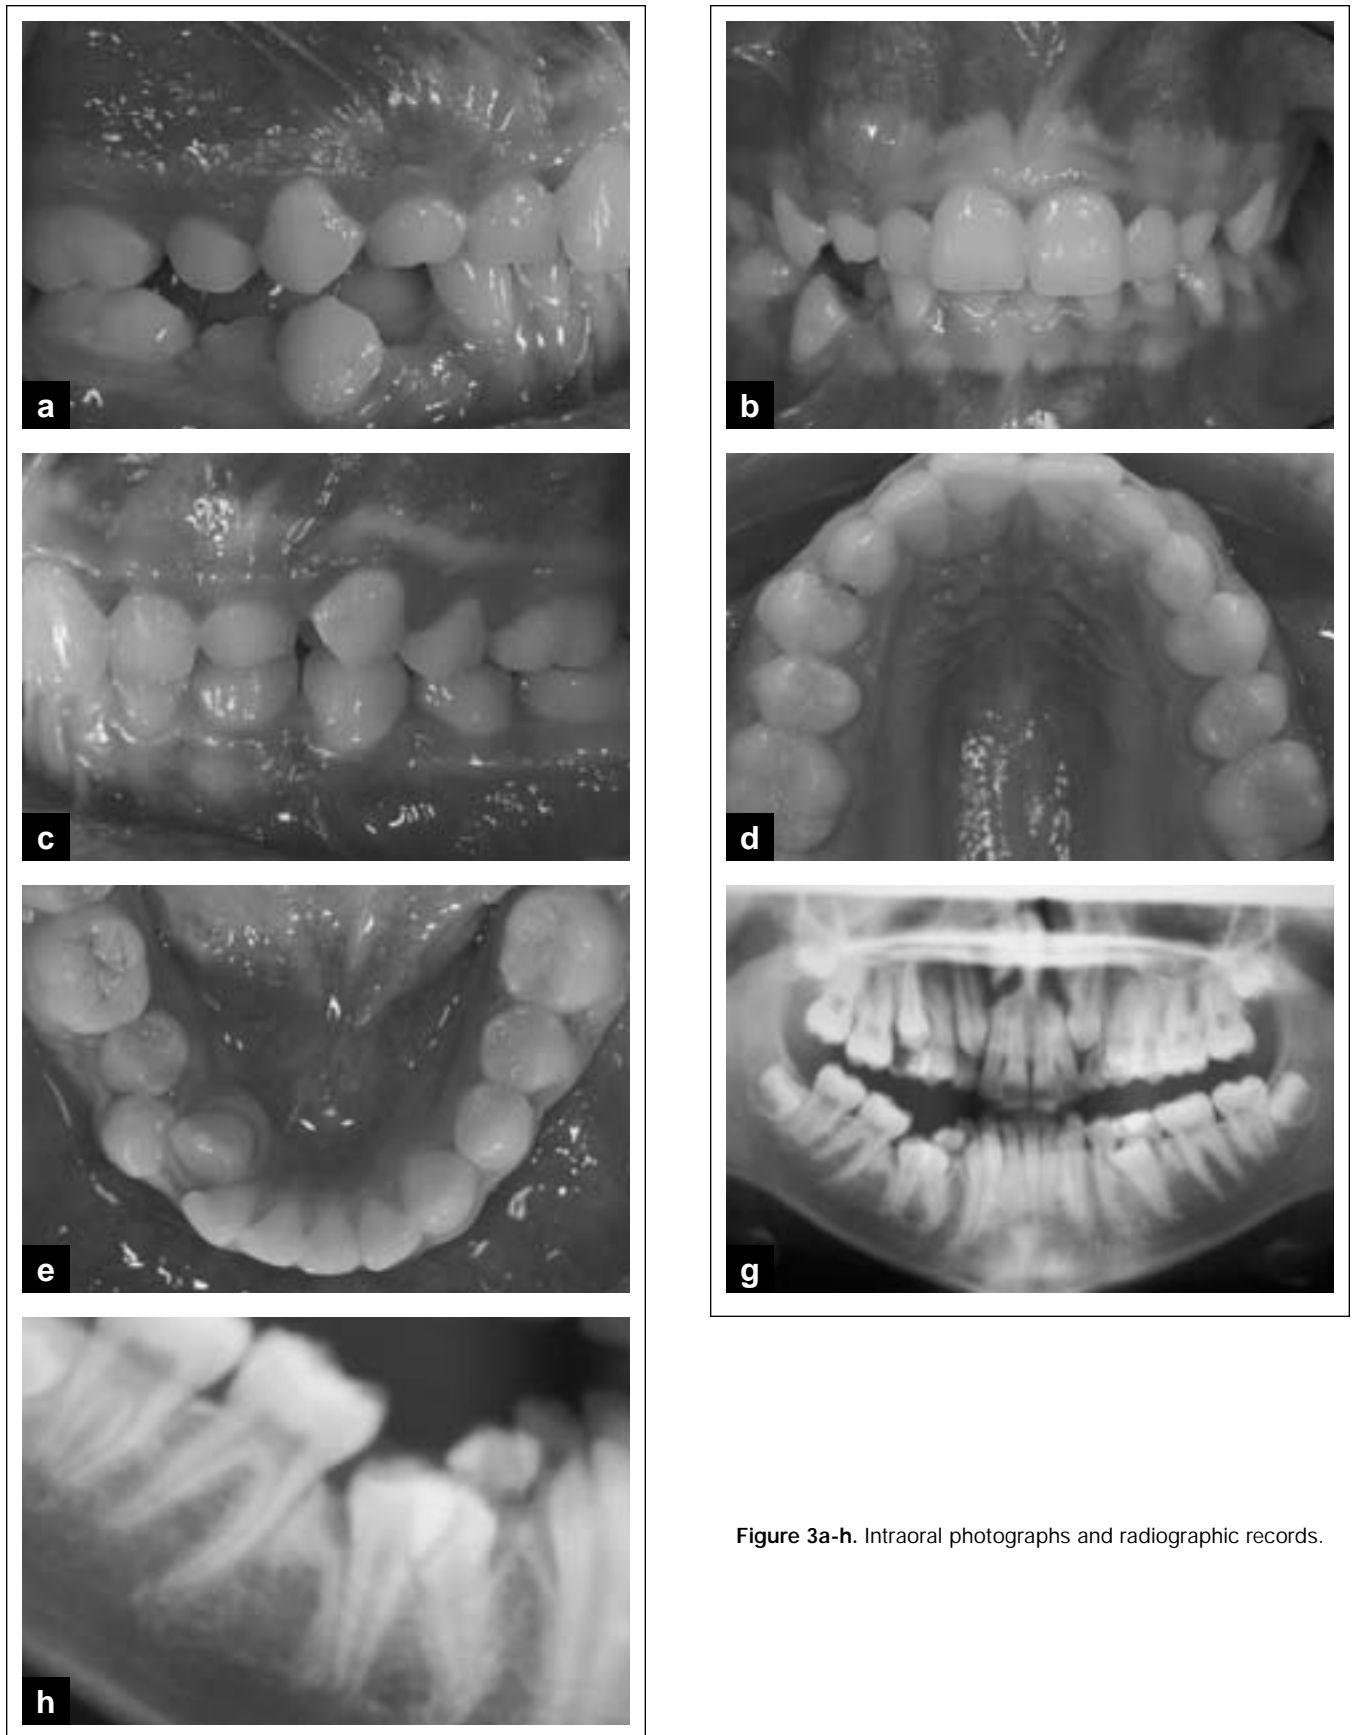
Intraoral photographs and radiographic records.
